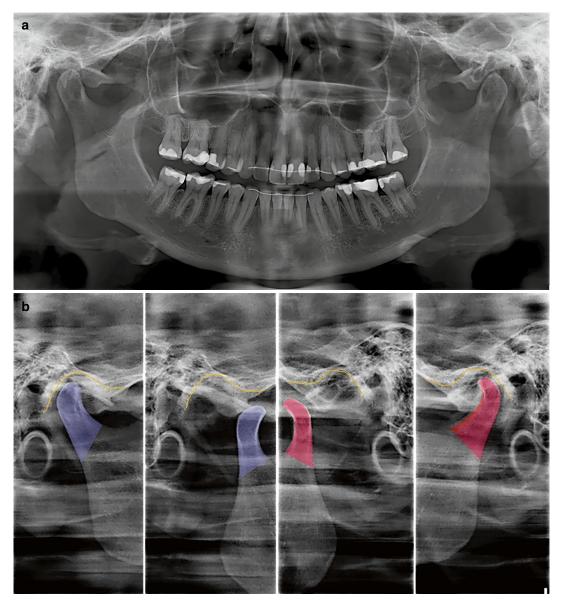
(a) Panoramic and (b) TMJ plain films of the patient with condyle color highlights
